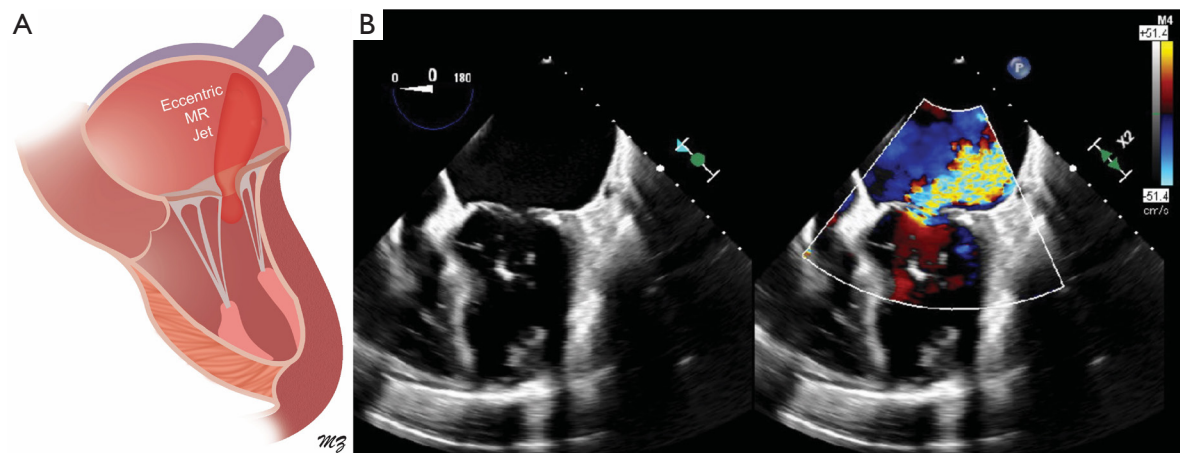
Left atrial dilation can lead to posterior mitral annulus displacement and loss of mitral valve coaptation leading to secondary MR with characteristic eccentric jet. (A) Atrial secondary MR due to progressive left atrial and mitral annular dilatation leading to displacement of the posterior mitral annulus onto the crest of the LV inlet. This presents with an eccentric jet. (B) TEE ME four chamber view of atrial secondary MR due to progressive left atrial and mitral annular dilatation leading to displacement of the posterior mitral annulus onto the crest of the LV inlet. This presents with an eccentric jet. MR, mitral regurgitation; TEE, transesophageal echocardiogram; LV, left ventricular; ME, mid-esophageal.
